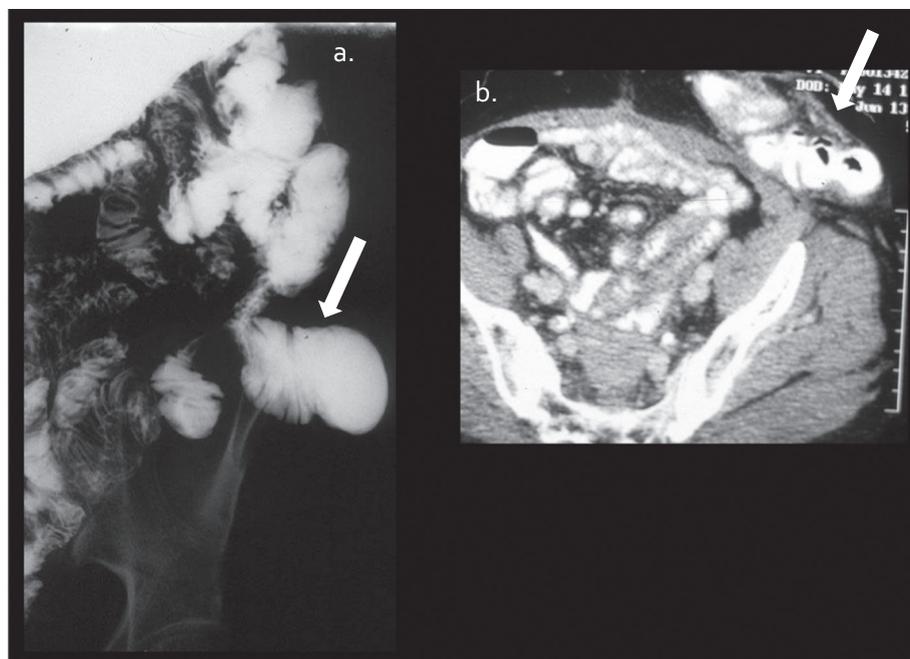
Parastomal hernia: images from small bowel series (a) and axial CT scan with oral and IV contrast (b) demonstrates parastomal hernia containing non-obstructed small bowel (arrow).
